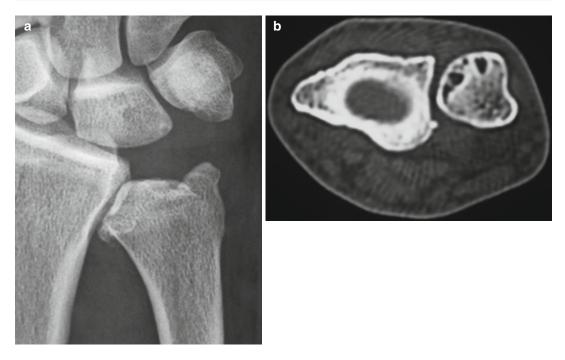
(a) Antero-posterior radiograph of the DRUJ showing joint irregularity and small proximal osteophytes. (b) CAT scan demonstrating subchondral cysts on the head of the ulna
